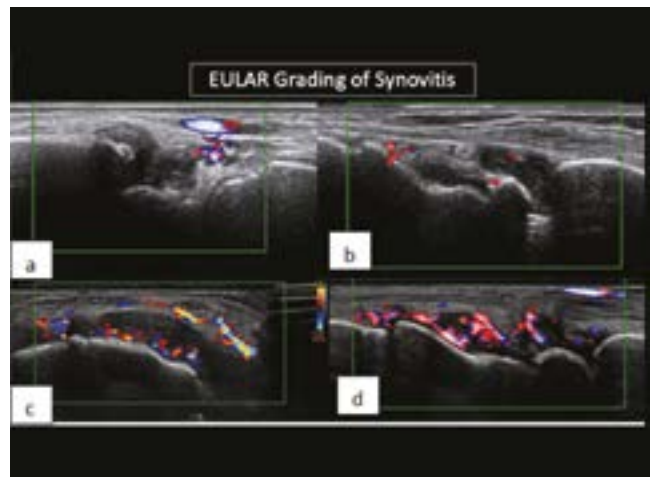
Grading of synovitis – USG of the wrist joint of different patients show grade-I (a), grade-II (b), grade-III (c) and grade-IV (d) synovitis as indicated by area of involvement by power doppler signal
